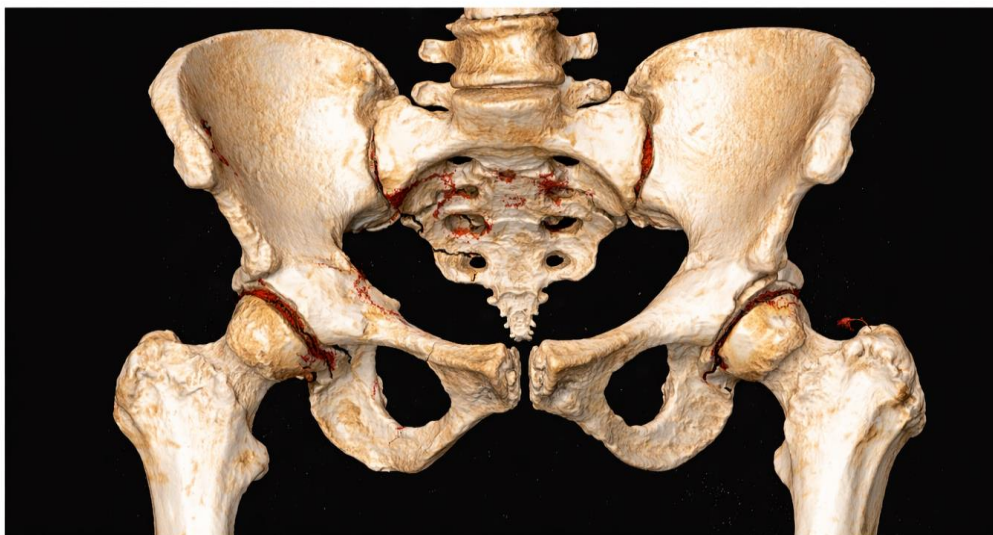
CT-based three-dimensional reconstruction for complex fracture characterization. 3D CT reconstruction improves visualization of comminution and intra-articular extension, supporting surgical planning and fixation strategy
